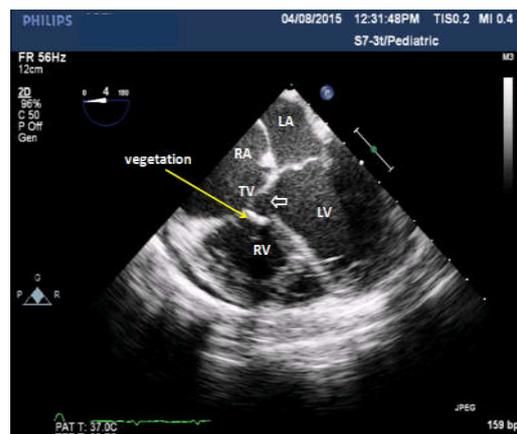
2D transesophageal echocardiography, midesophageal 4-chamber view shows a large (12 mm×5 mm) mobile vegetation over the septal leaflet of tricuspid valve, perimembranous ventricular septal defect extends into inlet (open white arrow) (LA: left atrium, LV: left ventricle, RA: right atrium, RV: right ventricle, TV: tricuspid valve)
